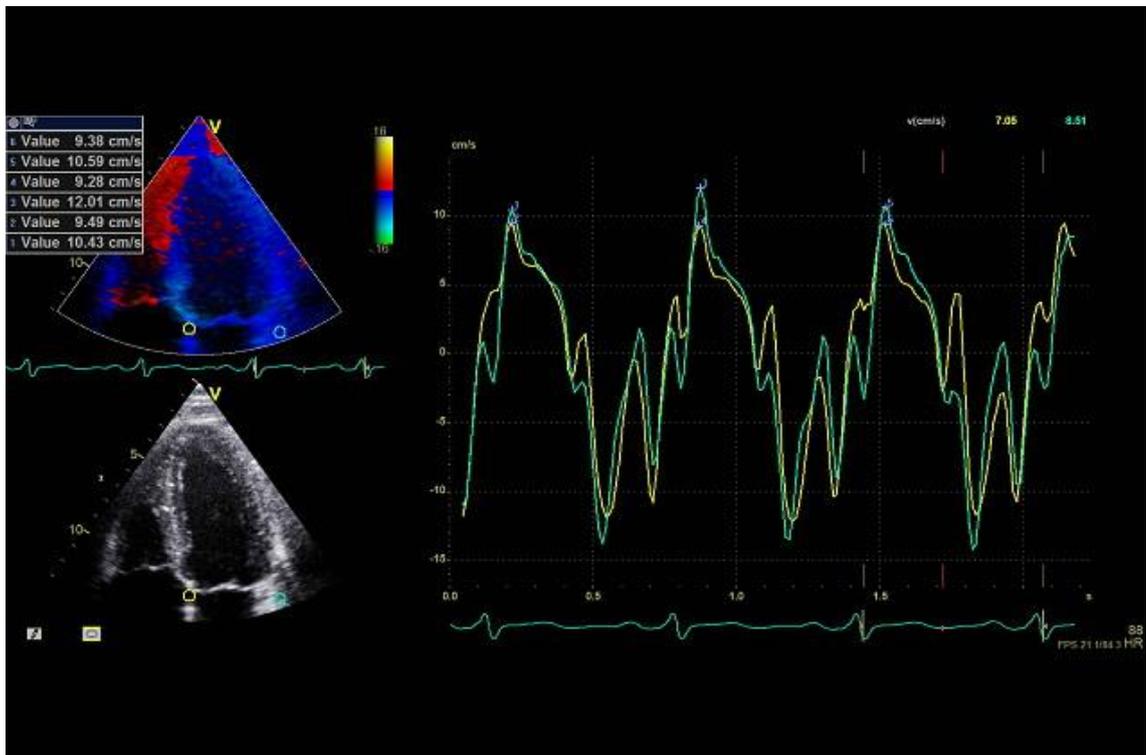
Colour tissue Doppler: an example of normal systolic velocity in the lateral and septal wall
